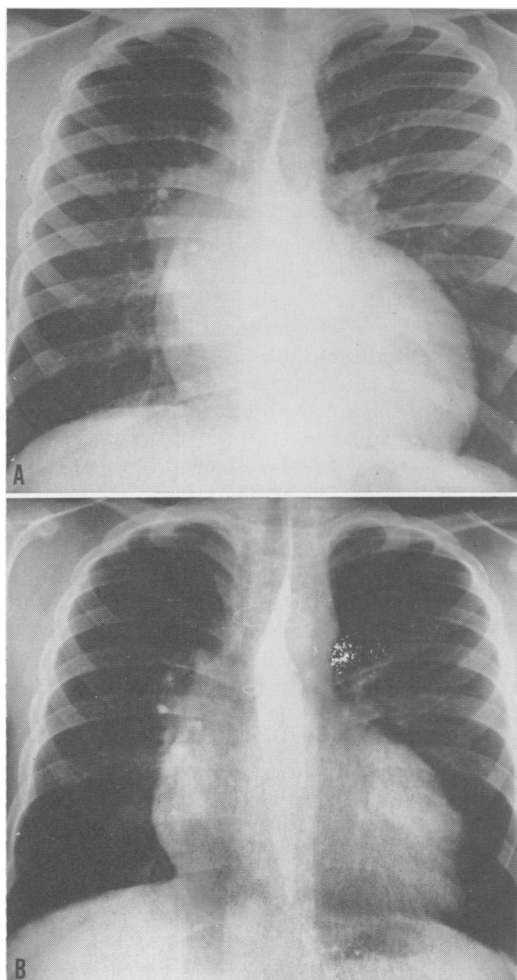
Preoperative (A) and postoperative (B) chest x-rays of patient C. F.
